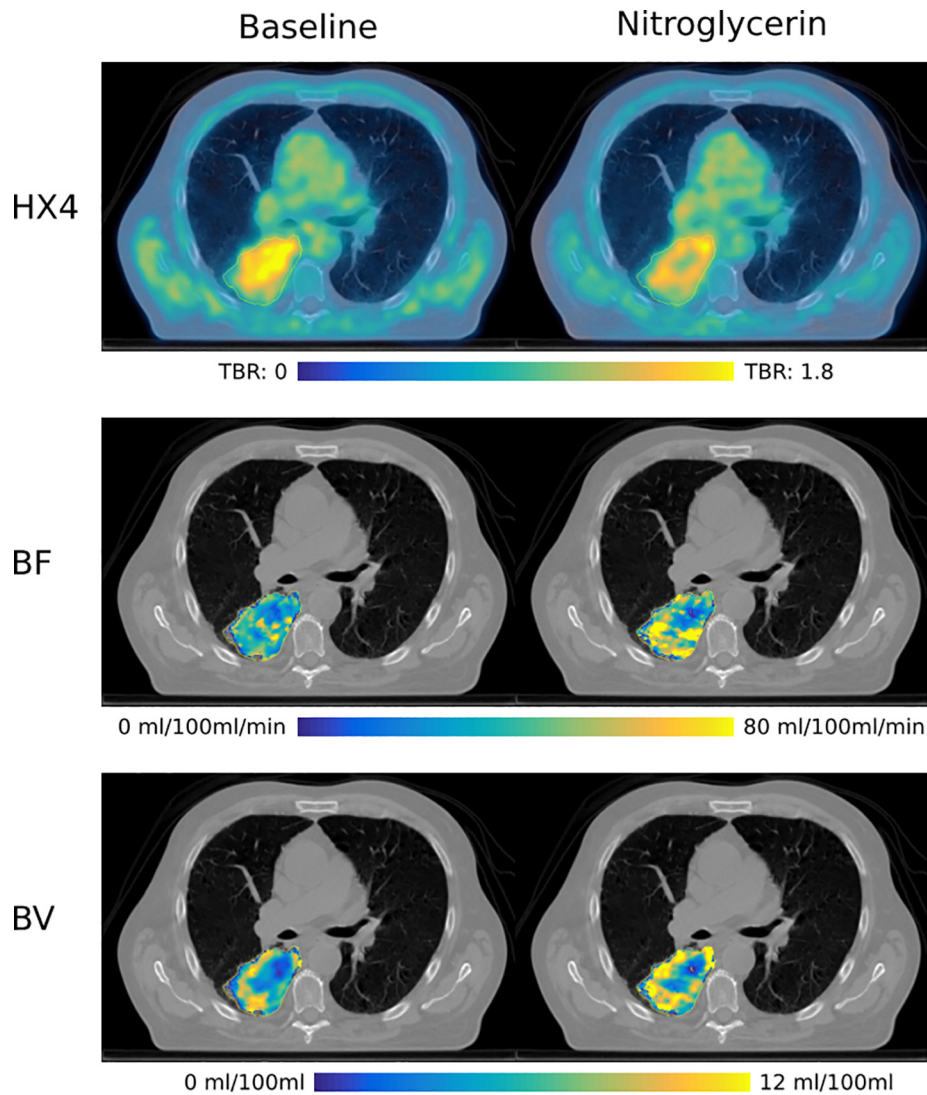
HX4-PET/CT scan, blood flow (BF) and blood volume (BV) DCE-CT maps of a representative patient, at baseline and after applying a nitroglycerin patch. In this patient, the hypoxic volume decreased from 70 cm³ to 64 cm³, while the average BF increased from 37 ml/100 ml/min to 54 ml/100 ml/min, and the average BV increased from 5.8 ml/100 ml to 8.6 ml/100 ml.
